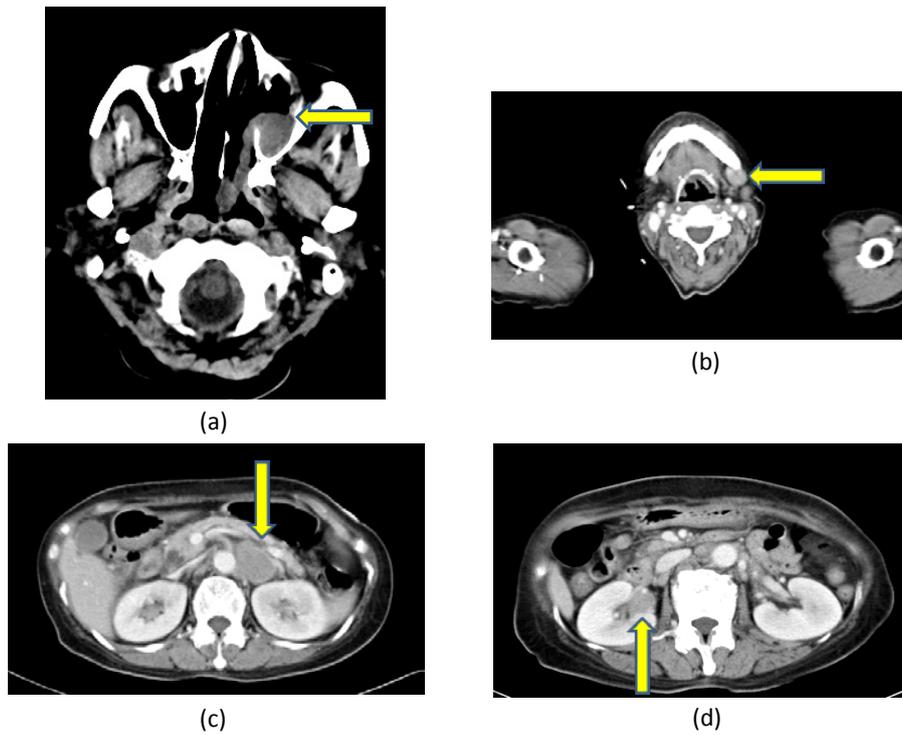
(a) Head CT showing the mass located from the left maxillary sinus to pharyngeal cavity, (b)(c)(d)Chest and Abdominal CT showing the multiple masses: (b)located on the left submaxillary region, (c)located on the left renal hilum region, (d) located on the right renal pelvis region (arrow)
